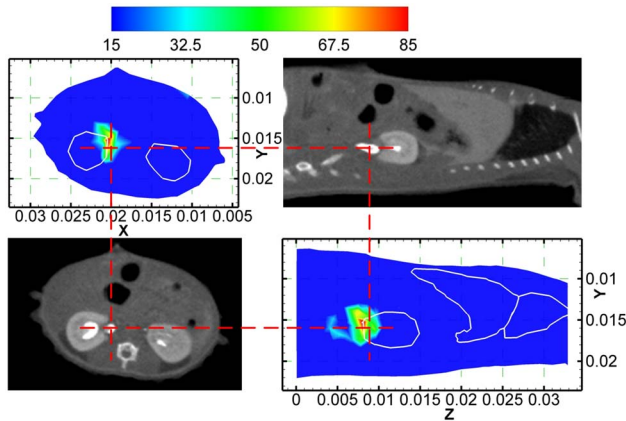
(Color online) Reconstruction results: transverse view of the results and comparisons with the corresponding CT slices. The cross of the red lines denotes the actual source center.
